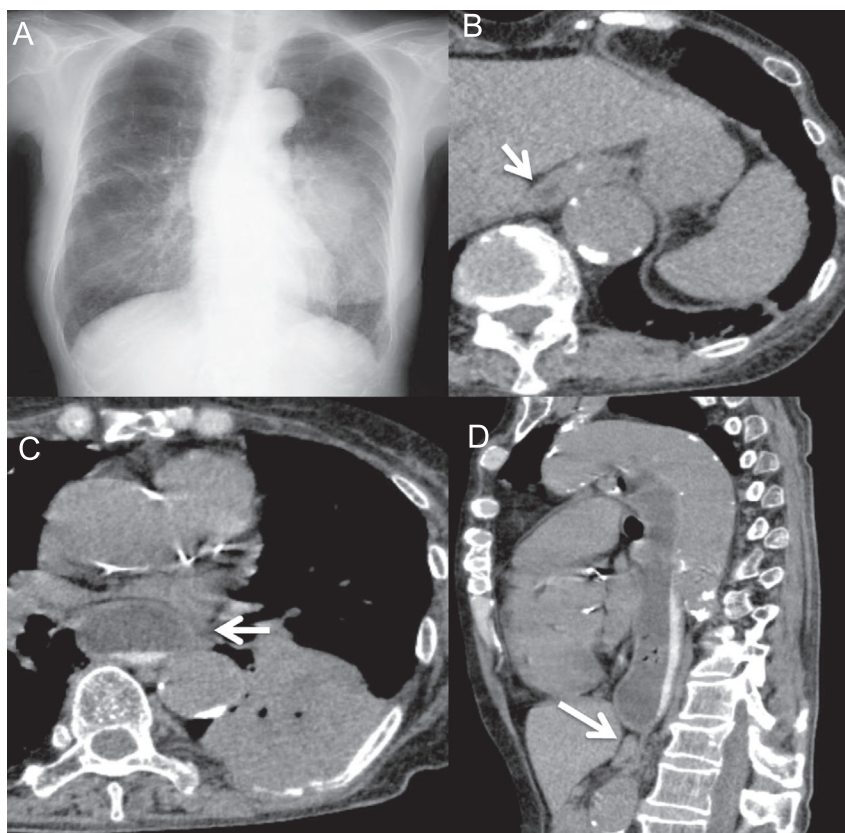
Chest radiography (A) and computed tomography (CT) (B and C, coronal; D, sagittal) images are shown. Arrow on CT indicates stenosis of the lower esophageal sphincter (LES) and dilation of the upper esophageal sphincter; there was no direct compression of the lesion.
